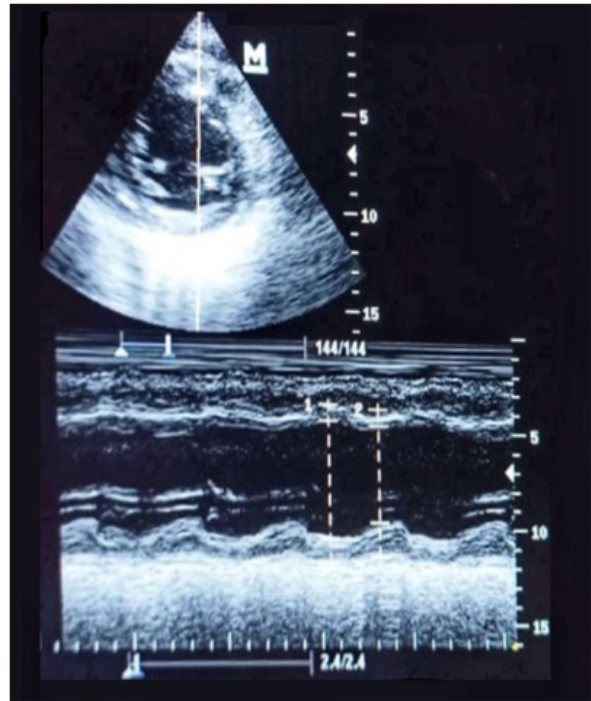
Echocardiography findings.
